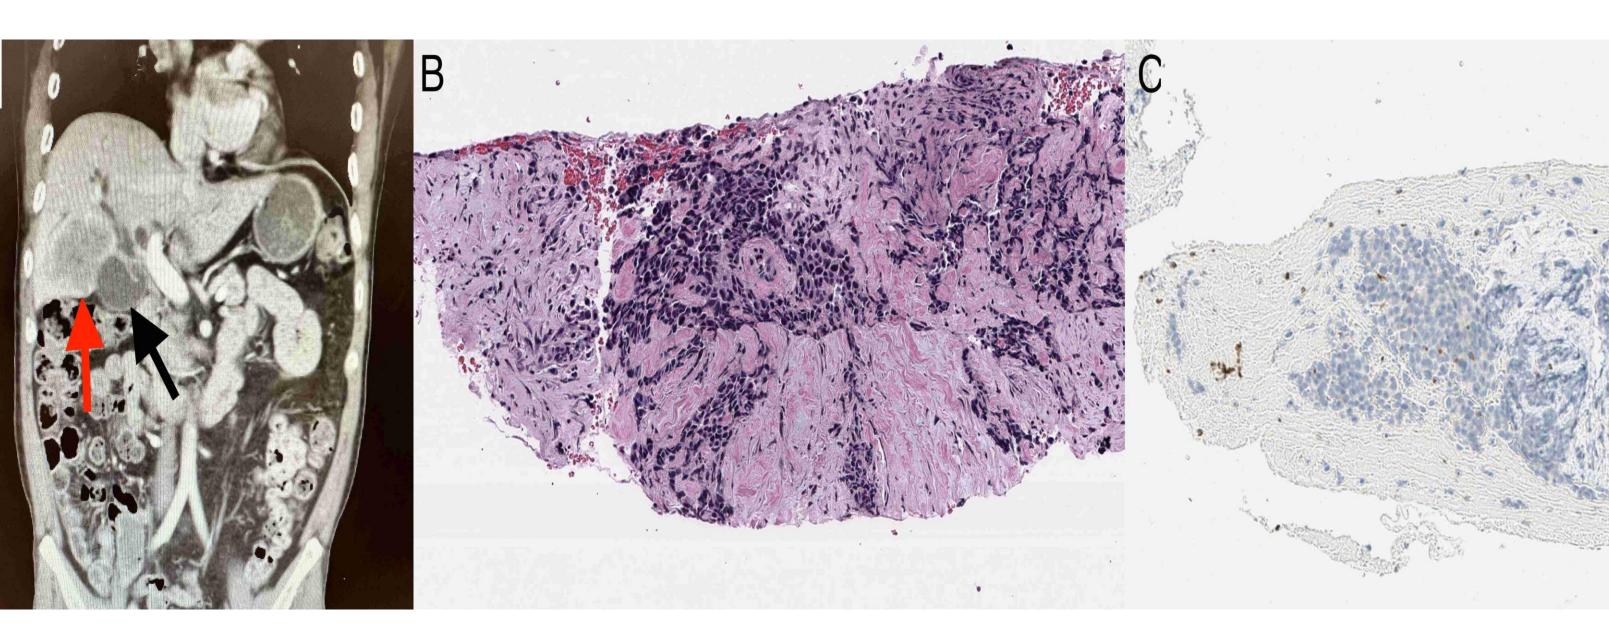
CT abdomen with IV contrast showing gallbladder wall thickening (black arrow) and infiltrates into the liver (red arrow).
